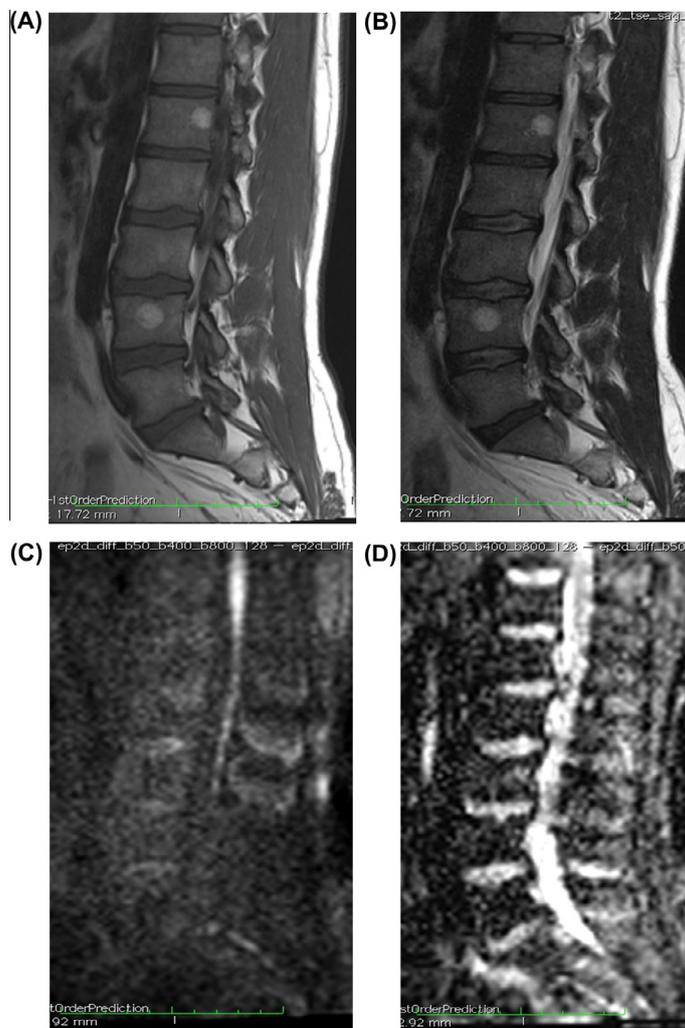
Sagittal T1 (A) and Sagittal T2 (B) weighted images showing focal T1 and T2 hyper-intense lesion at LV4 and LV1 vertebral bodies with low signal at DWI (C) and subtle high signal at ADC map (D)...features of typical vertebral hemangiomas.
